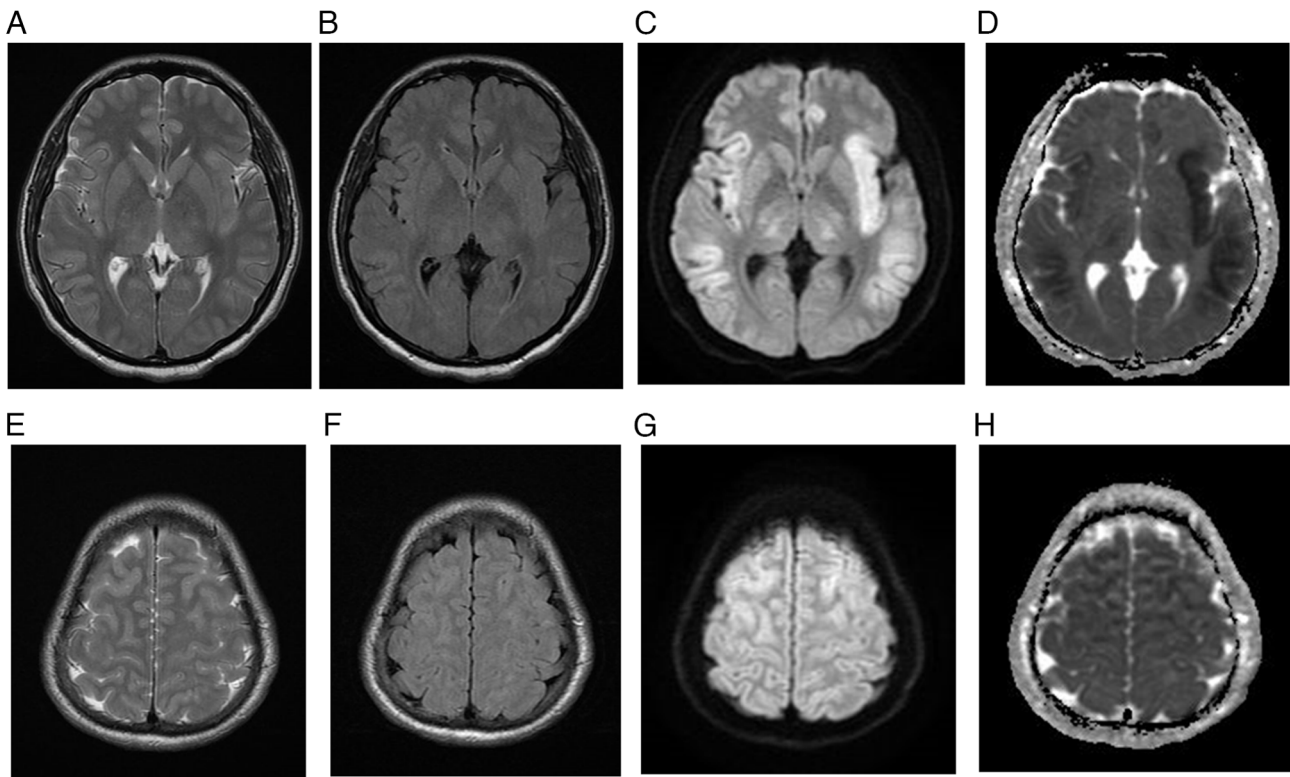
Initial brain MRI for case 1. (A) T2-weighted MRI, (B) FLAIR, (C) DWI and (D) ADC map demonstrating asymmetric cortical high T2 and FLAIR signal intensity involving the bilateral insular cortex, temporal lobes, cingulate gyri and bilateral lateral thalami with corresponding diffusion restriction. The bilateral occipital lobes are spared. At the level of vertex, (E) T2-weighted image, (F) FLAIR image, (G) DWI and (H) ADC map demonstrating symmetric cortical high T2 and FLAIR signal intensities involving the frontal and parietal lobes with corresponding restricted diffusion. The bilateral peri-Rolandic regions are spared. FLAIR, fluid-attenuated inversion recovery; DWI, diffusion-weighted imaging; ADC, apparent diffusion coefficient.
